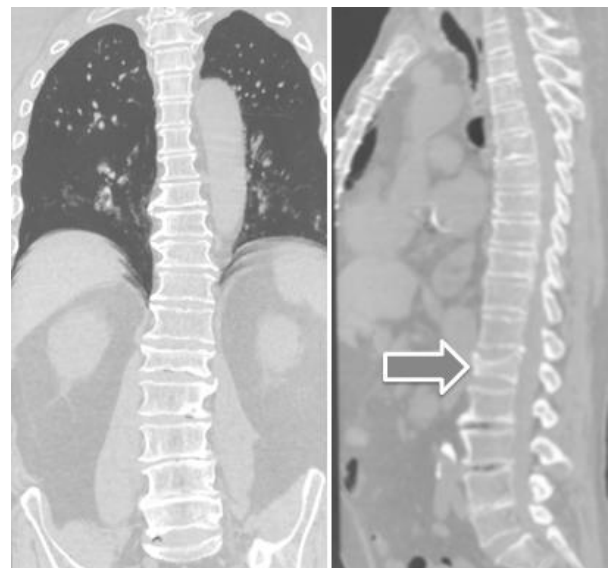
Spine CT scan. Arrow is pointing at L1 vertebral body compression fracture without signs of dislocation. No other pathological finding was found.
